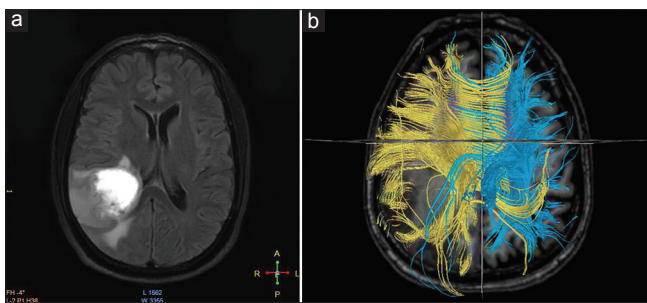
(a) A 52-year-old male patient presented with left-sided weakness and headache. Magnetic resonance imaging shows the right parietal mass. Total resection of tumor was performed. Postoperatively, patient has improvement in power. (b) Diffusion tensor imaging shows displacement of the white matter tracts
